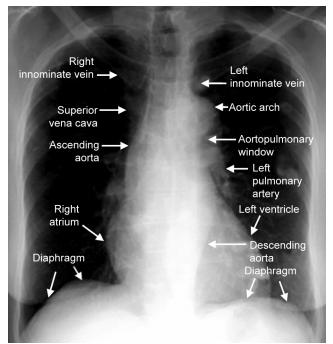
The specific anatomy of the PA chest X-ray
